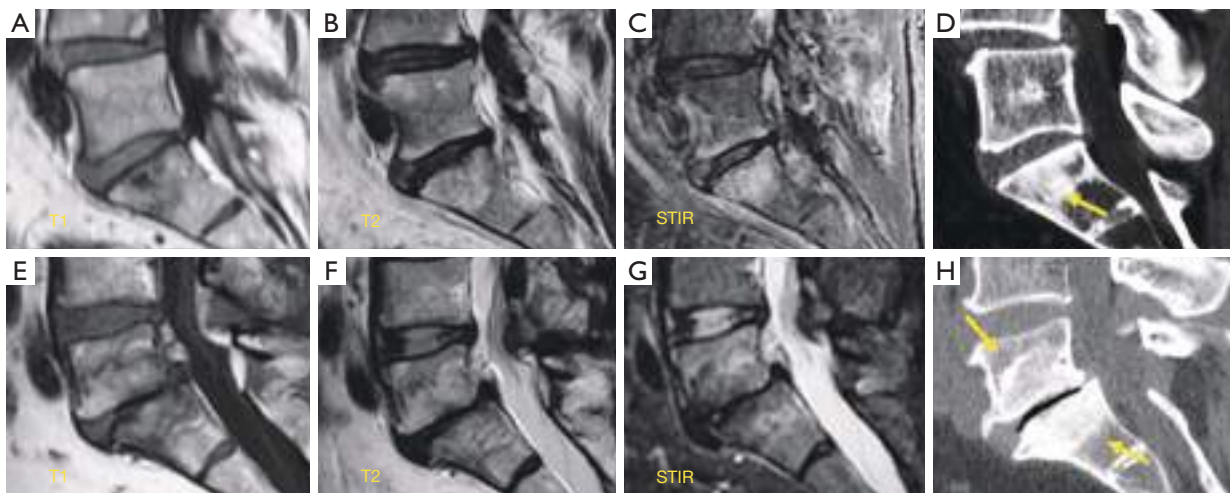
Modic changes. Sagittal T1 weighted image (A), T2 weighted image (B) and STIR sequence image (C) of Modic type I changes. Sclerosis (arrow) detected at S1 on CT (D) is barely visible on MRI. Sagittal T1 weighted image (E), T2 weighted image (F) and STIR image sequence (G) of Modic type II changes. Sclerosis (arrows) conspicuous on CT (H) is barely suspected on MRI. STIR, short tau inversion recovery; CT, computed tomography; MRI, magnetic resonance imaging.
